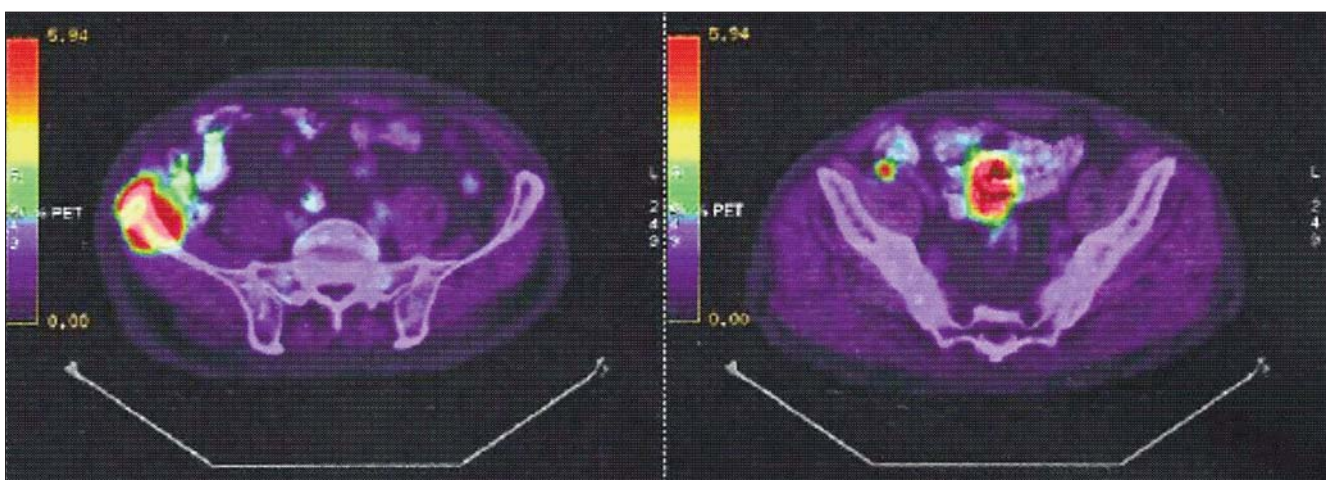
PET-CT scan revealing tumour recurrence – polyp of the sigmoid colon with malignant evolution and right iliac tumour mass
